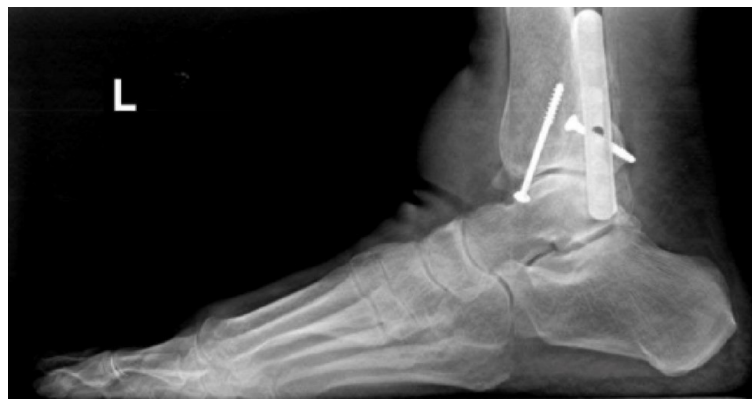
Lateral view radiograph showing increase in soft tissue volume & density anterior to the tibio-talar joint in the area of soft tissue mass.
